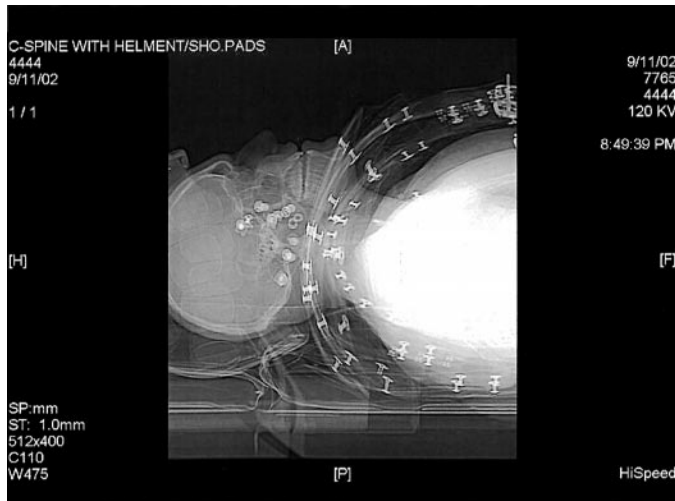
Lateral scout film from standard computed tomography (CT) examination. Note the numerous metallic snaps and clips overlying the upper cervical spinal column. The shoulders obscure the view of the cervicothoracic junction.
